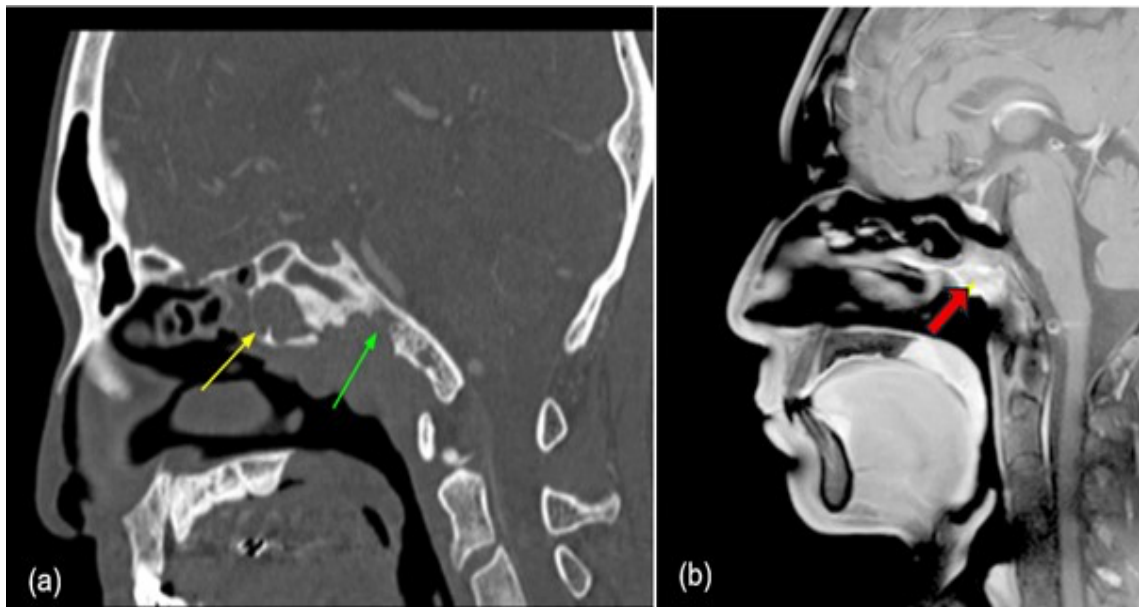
The imaging done pre and post treatment. (a) CECT PNS (sagittal view) shows erosion of sphenoid sinus (yellow arrow) and clivus (green arrow). (b) MRI paranasal sinuses 3 months post steroid treatment shows reducing size of nasopharyngeal mass (red arrow)
